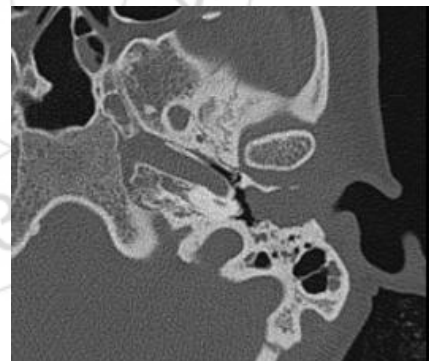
Axial temporal bone CT image – soft tissue mass filling the EA C with anterior and posterior wall erosion.
